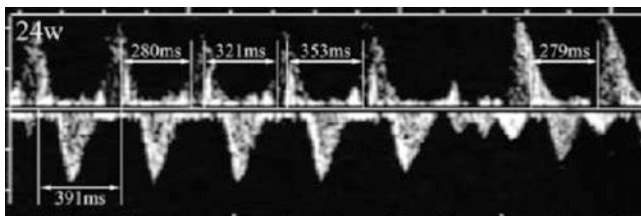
Second-degree heart block, type I. This simultaneous SVC/AA Doppler recording shows the venous waves are below the zero-velocity line and the aortic waves above the line. A tall “A” wave is superimposed on the aortic wave. The progressive lengthening of the AV time intervals from 280 to 353 ms leads to a complete block, observed in a classical Luciani–Wenckebach phenomenon. It should be noted that the A-A interval remains constant at 391 ms. (References: Fouron JC. Fetal arrhythmias: the Saint-Justine hospital experience. *Prenat Diagn*, 2004, 24:1068–1080.)
